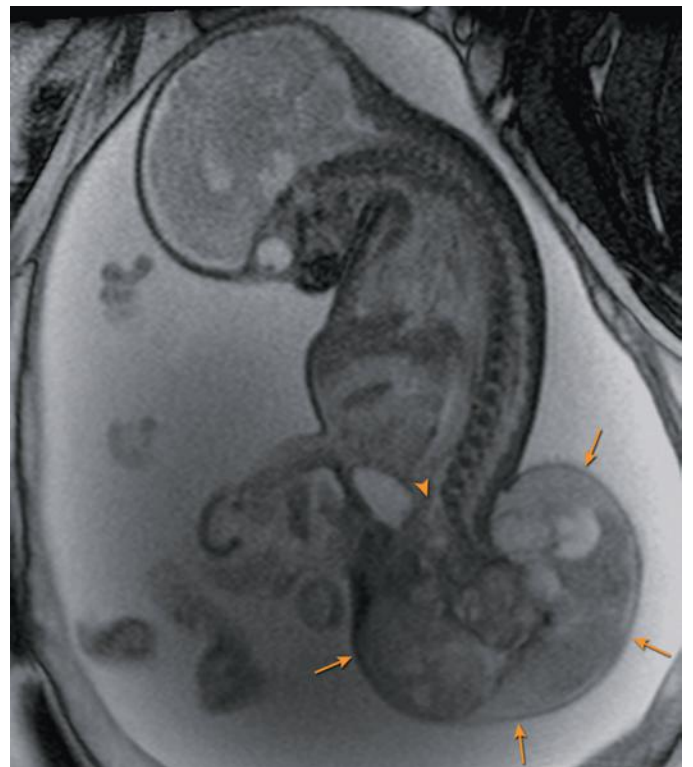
Sacrococcygeal teratoma at 26 weeks' gestation. Sagittal T2-weighted imaging demonstrates a large complex exophytic cystic and solid sacrococcygeal mass (arrows) with minimal intrapelvic extension in the presacral region (arrowhead).
